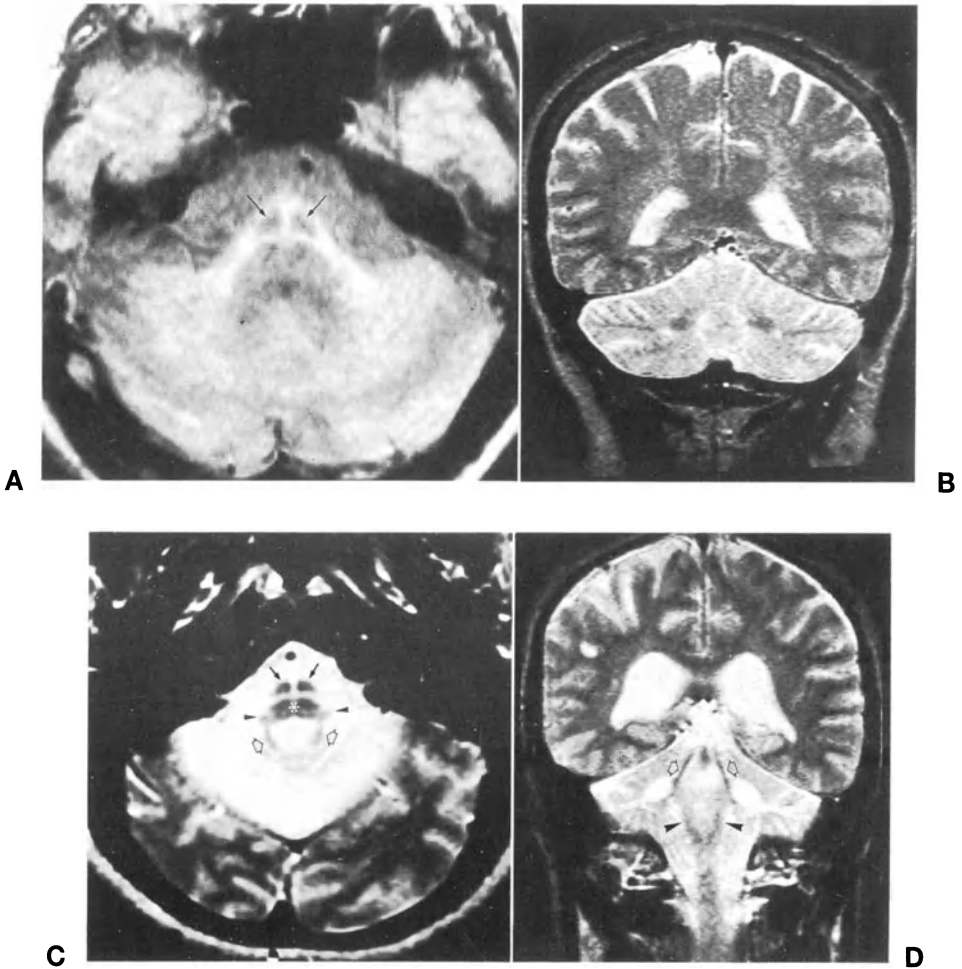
Olivopontocerebellar atrophy. Signal hyperintensity is visible in T2-weighted and mainly in proton density images in the degenerate transverse pontine fibers and middle cerebellar peduncles (A axial proton density section; compare with Fig. 10; arrows indicate the normal pyramidal tracts). Cerebellar hyperintensity is particularly well demonstrated in coronal sections, by comparison with the cerebral hemispheres (B). The structures that in OPCA do not degenerate stand out by their normal signal intensity; these are: pyramidal tracts (arrows), pontine tegmentum (asterisk), inferior cerebellar peduncles (arrowheads), superior cerebellar peduncles (open arrows), (C T2-weighted axial section). The normal inferior (arrowheads) and superior (open arrows) cerebellar peduncles may be seen against the abnormal background in coronal section (D). [C and D, from Radiology (Savoirdo et al., 1990), with permission]
